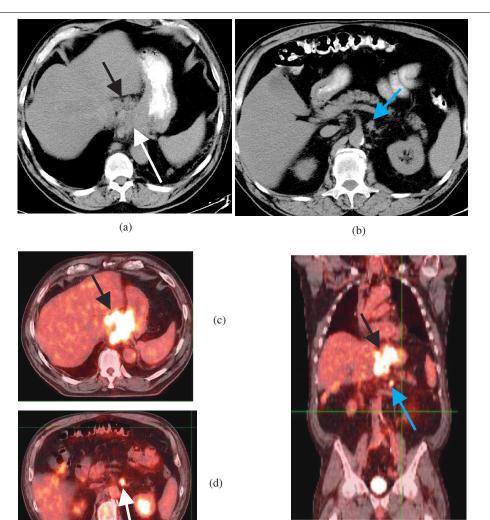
Primary distal esophageal adenocarcinoma with regional and distant lymph node metastases. CT shows thickening of the distal esophagus (white arrow) with adjacent enlarged, regional lymph nodes (black arrow) (a) and a small lymph node adjacent to the superior mesenteric artery (distant lymph node) (blue arrow, b). FDG uptake is seen not only within the primary tumor and adjacent lymph nodes (black arrow, c and e), but also within the small distant lymph node (blue arrow, d) on the fused PET-CT images; distant lymph node disease contraindicated surgical resection.
